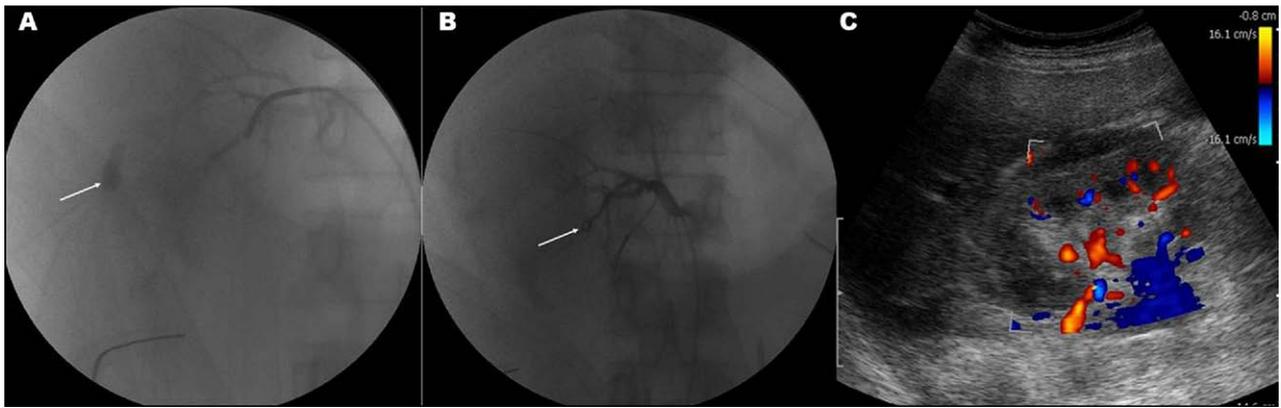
(A) Angiogram showing right upper polar arteriovenous fistula (AVF, arrow) in 40-year-old woman referred to us with bleeding after bilateral simultaneous percutaneous nephrolithotomy. (B) Postsuperselective embolization angiogram from same patient showing complete occlusion of offending vessel with metallic coil (arrow). (C) Doppler ultrasound image, on follow-up, of same patient, showing good vascularity.
